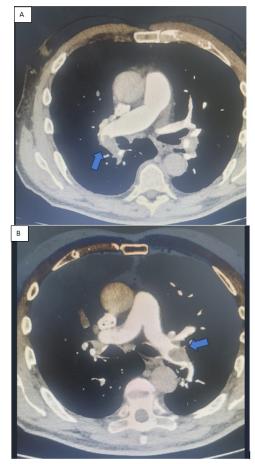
CT pulmonary angiogram scan showing extensive acute bilateral pulmonary emboli (A) Left pulmonary arteries. (B) Right pulmonary arteries.
